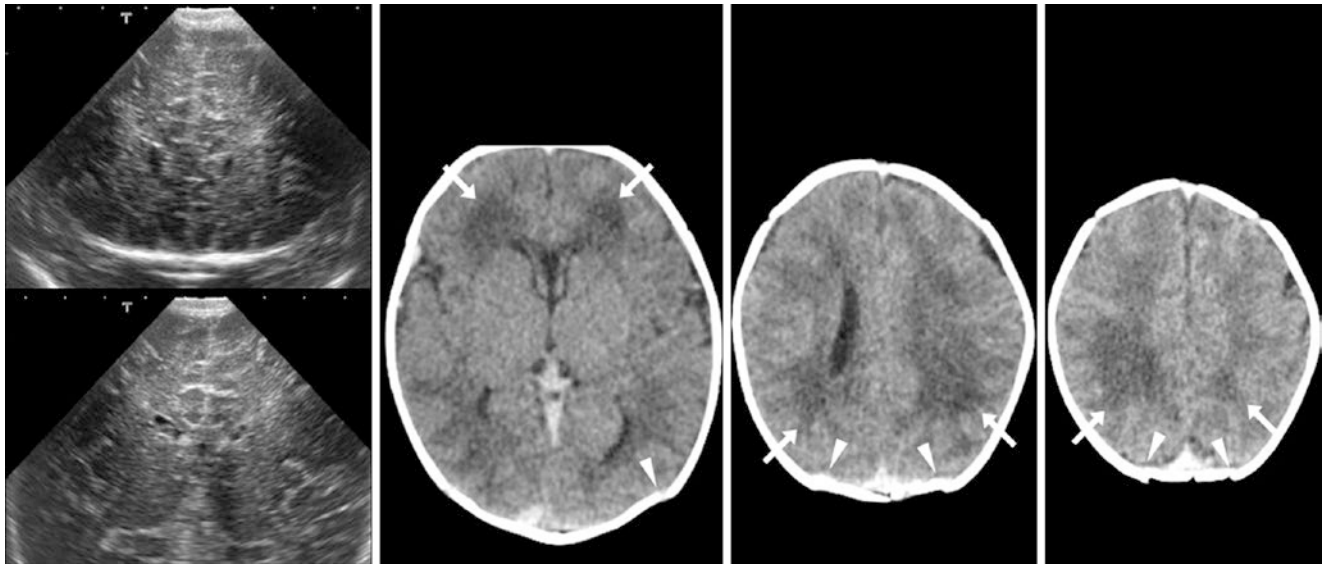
A 3-day-old term neonate with decreased responsiveness had a coronal ultrasound (*left*), which was questioned to have a tiny amount of intraventricular hemorrhage. An otherwise negative NECT the next day
